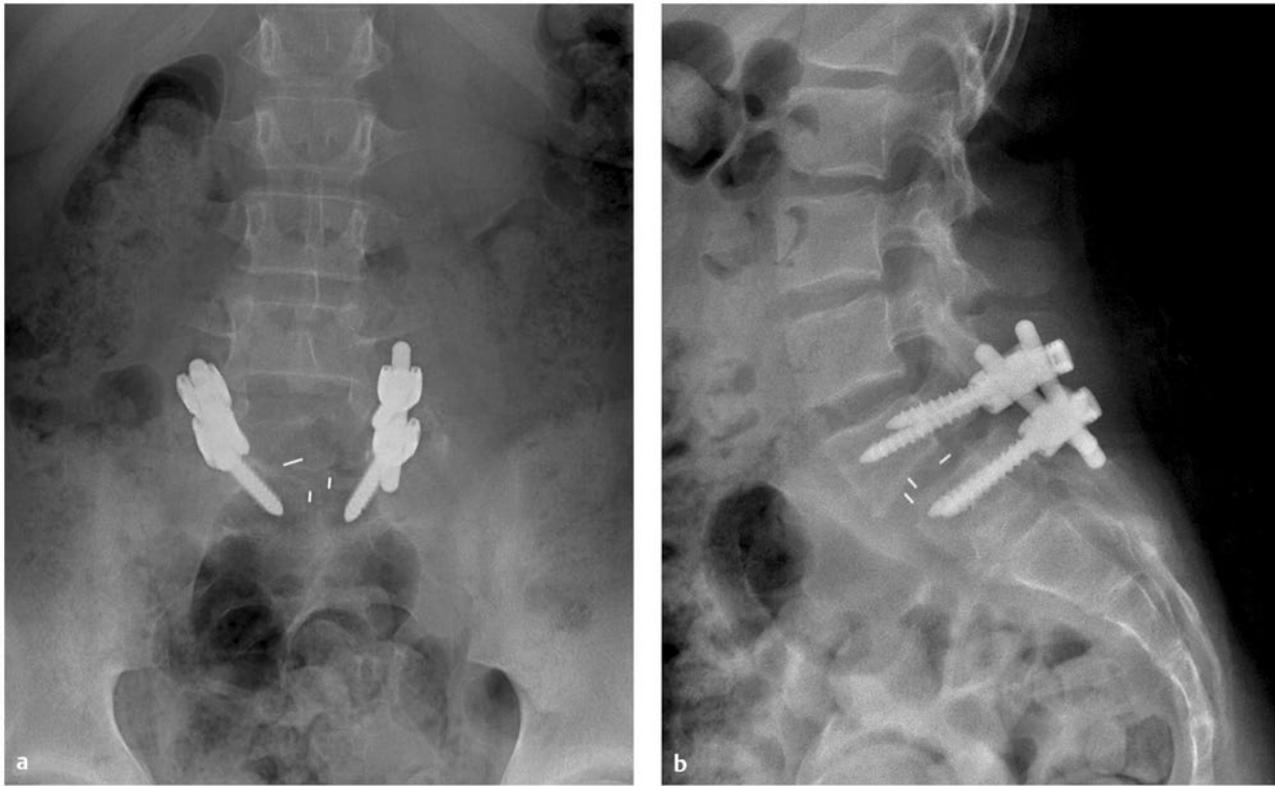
Spondylolysis with spondylolisthesis. Postoperative (a) anteroposterior and (b) lateral radiographs demonstrating L5–S1 transforaminal interbody fusion and L5–S1 posterior segmental instrumentation performed in the same patient as in ▶ Fig. 61.18.
